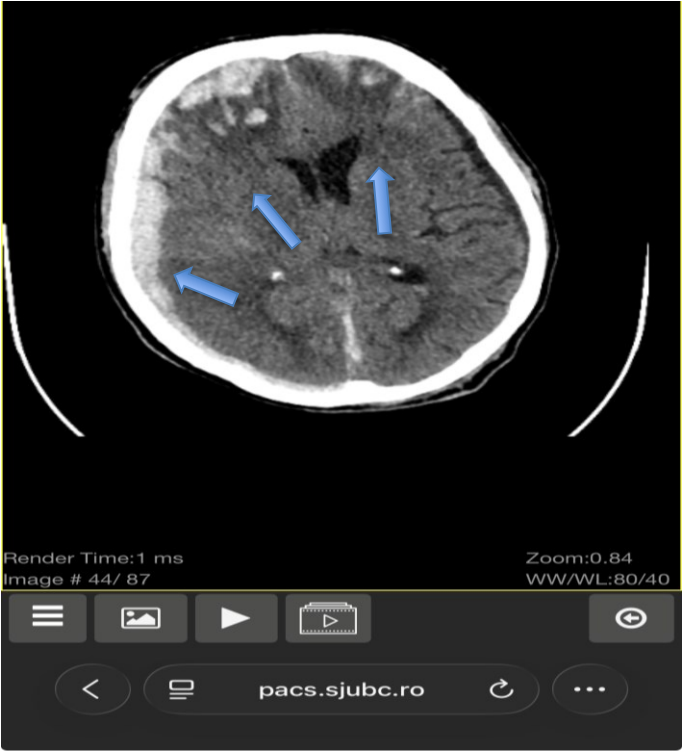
Fig. 1 Native brain CT examination performed on a patient with a head trauma, highlighting multiple brain injuries (Sources: SJU Bacău medical imaging database).
